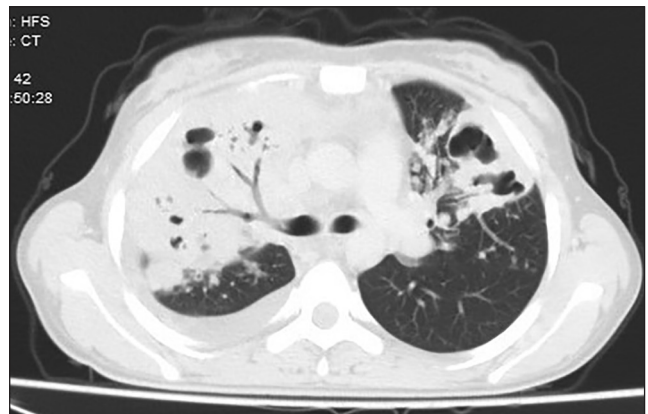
Cavitary infiltration on thorax CT
